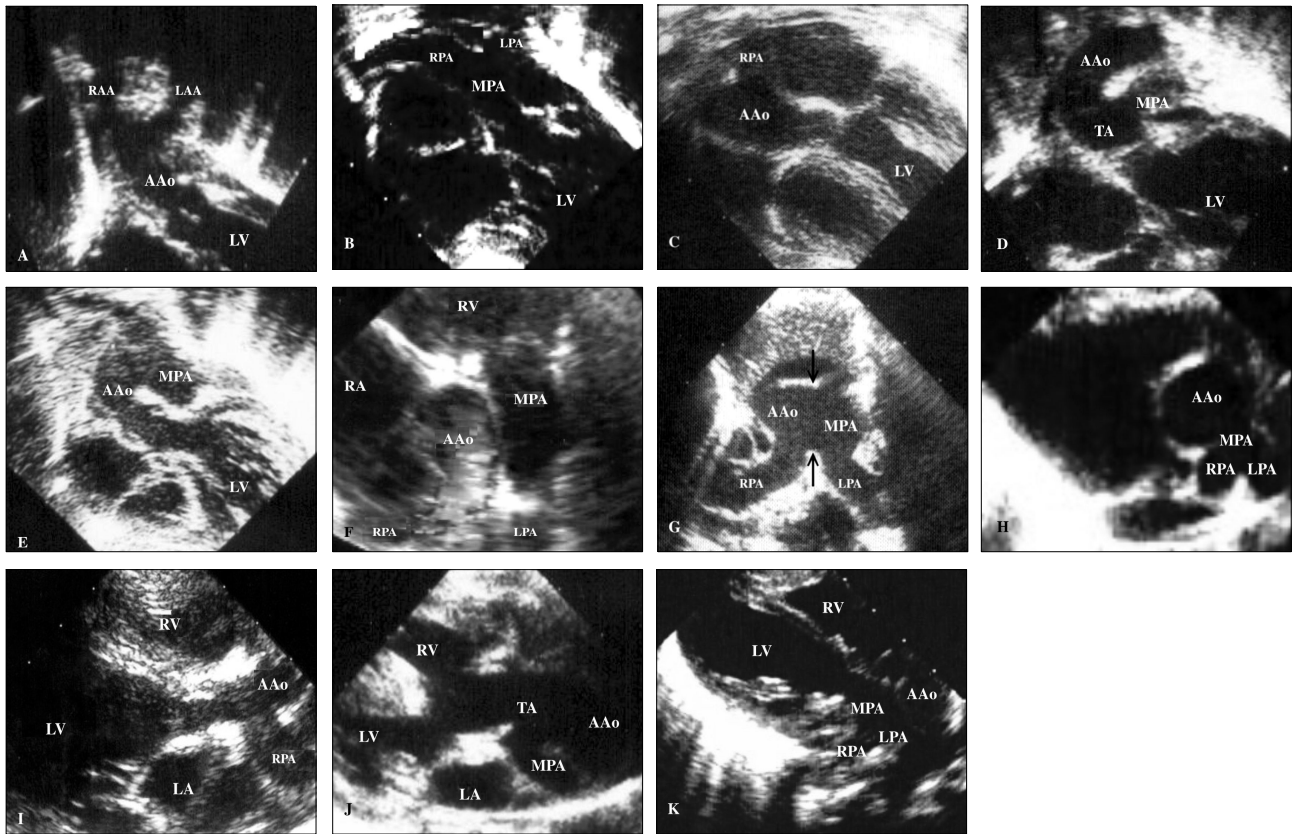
Subcostal view of the left ventricular outflow tract of echocardiography showed a characteristic morphology of the aortic bifurcations in cases with DAA (A), which has a longer bifurcation distance (from the semilunar valve to the site of bifurcation) than the bifurcation distance measured in cases with d-TGA (B), HTA (C), type I TA (D), and APW (E). Parasternal short-axis view showed an anomalous origin of the right pulmonary artery from the ascending aorta in a case of isolated HTA (F), and when complexed with APW (arrows) in the Berry syndrome (G), as well as an abnormal take-off of the main pulmonary artery from the left-posterior aspect of the aorta in cases with type I TA (H). Over the parasternal long-axis views, we may visualize bifurcation either from the ascending aorta, as in the case of HTA (I), or from the truncus in TA cases (J), which can be similar to d-TGA cases (K). AAo, ascending aorta; APW, aortopulmonary window; DAA, double aortic arch; d-TGA, dextro-transposition of the great arteries; HTA: hemitruncus arteriosus; LA, left atrium; LAA, left aortic arch; LPA, left pulmonary artery; LV, left ventricle; MPA, main pulmonary artery; RA, right atrium; RAA, right aortic arch; RPA, right pulmonary artery; TA, truncus arteriosus.
